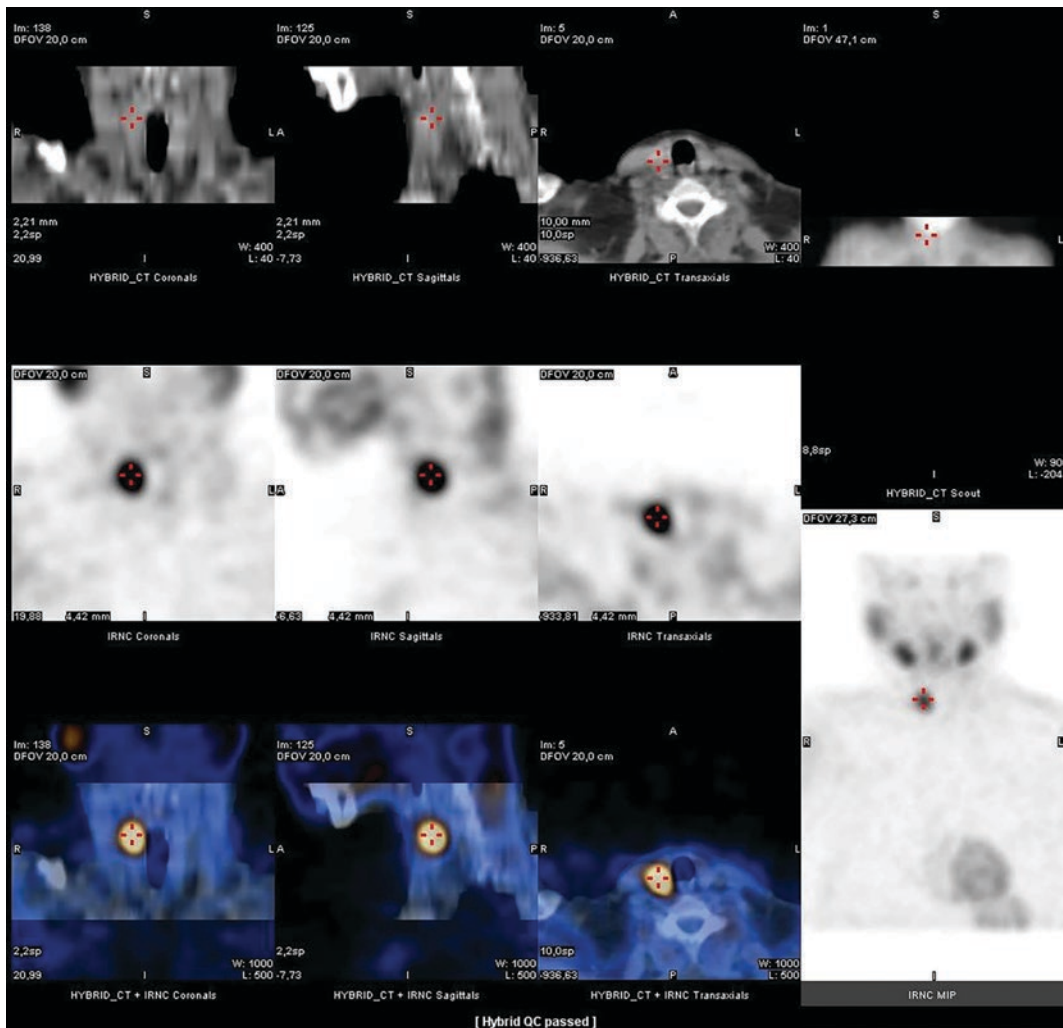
Corresponding sestamibi scintigraphy of hyperplastic parathyroid remnant in a patient with recurrent disease 13 years after subtotal parathyroidectomy. (With kind approval of Dr. M. Tosch, head of department of nuclear medicine, Helios university hospital, Wuppertal)
